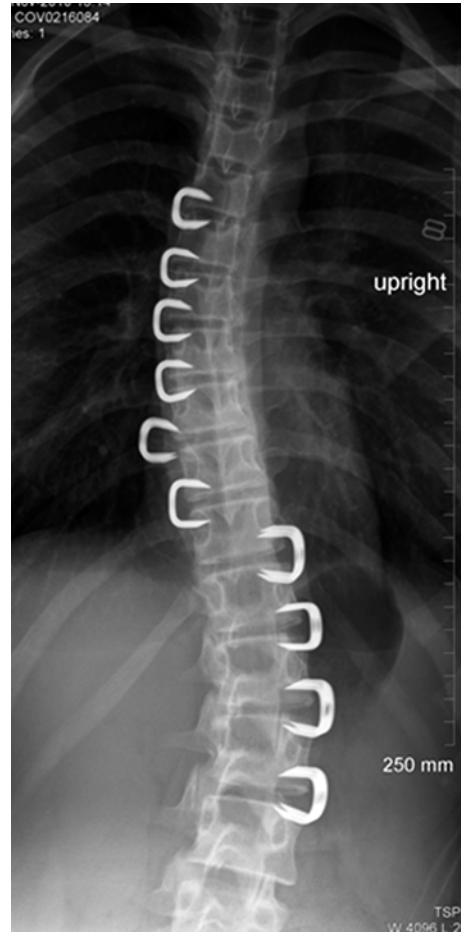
AP standing radiograph of a patient who is 2.5 years status post VBS with staple loosening at T9–T10
